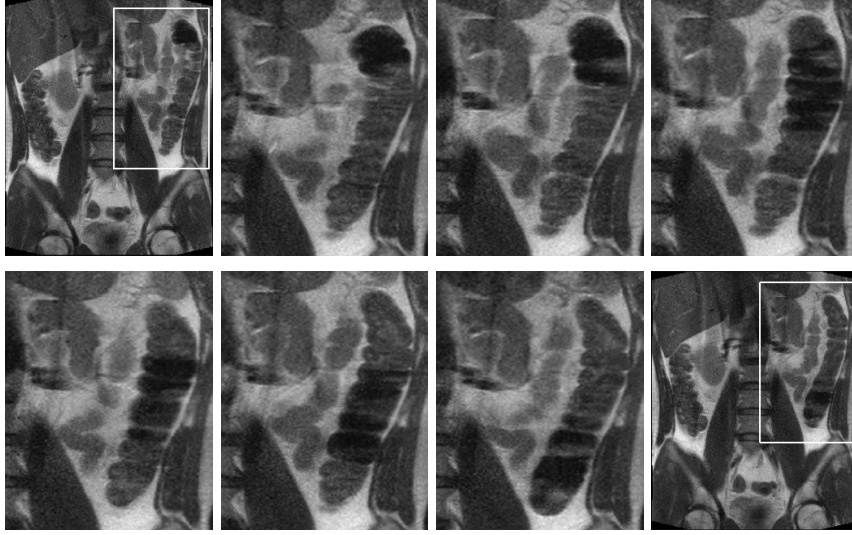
Coronal Cine MRI slices visualizing the peristaltic wave in the descending colon.
